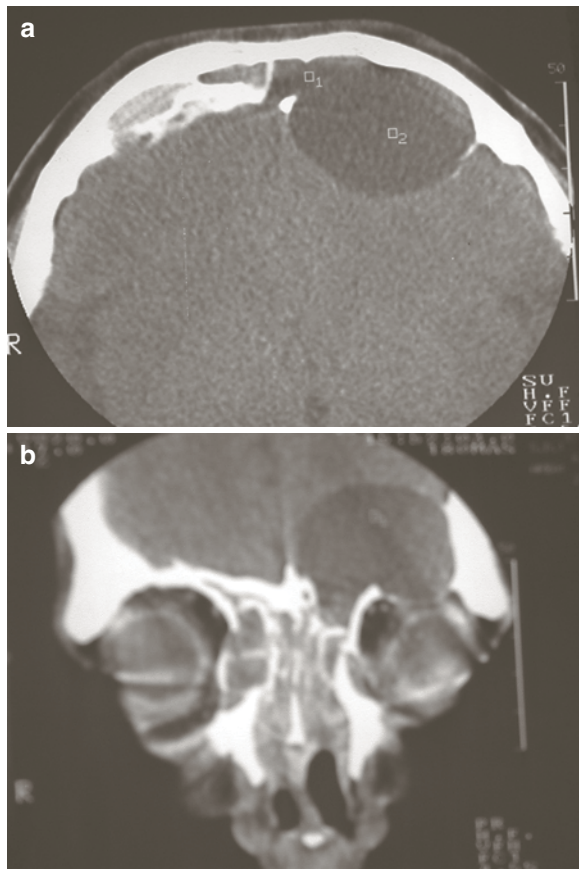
Mucocele in a patient with Samter syndrome with destruction of the posterior table of frontal sinus and superior orbital wall (a) Axial CT scan, (b) Coronal CT scan
